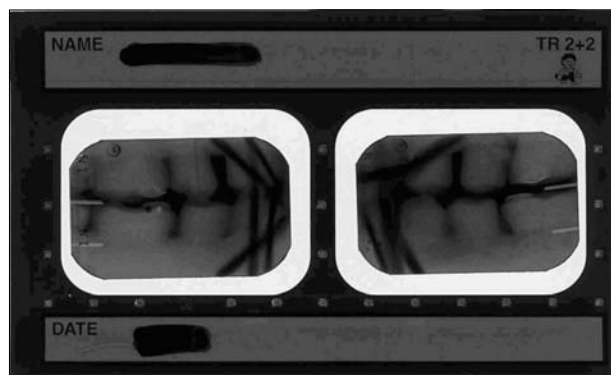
Example of radiographs taken to measure the posterior open bite.
